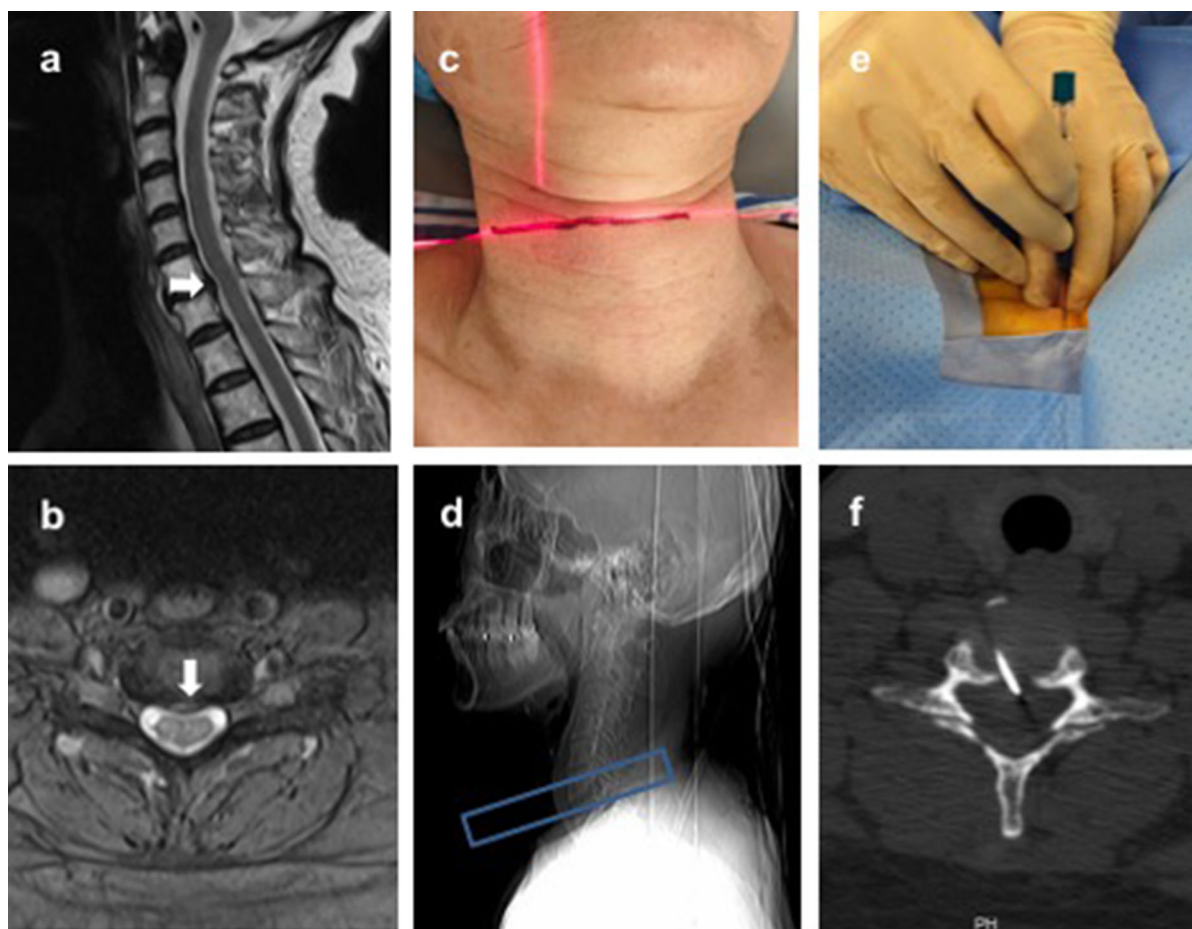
Radiofrequency ablation (RFA) of cervical intervertebral discs guided by computed tomography (CT). a, b Magnetic resonance imaging before RFA surgery showed mild central cervical disc herniation (white arrow) at C6–7. c, d CT scanner guidance was used to locate the target plane for cervical puncture. Blue box, scanning area.
